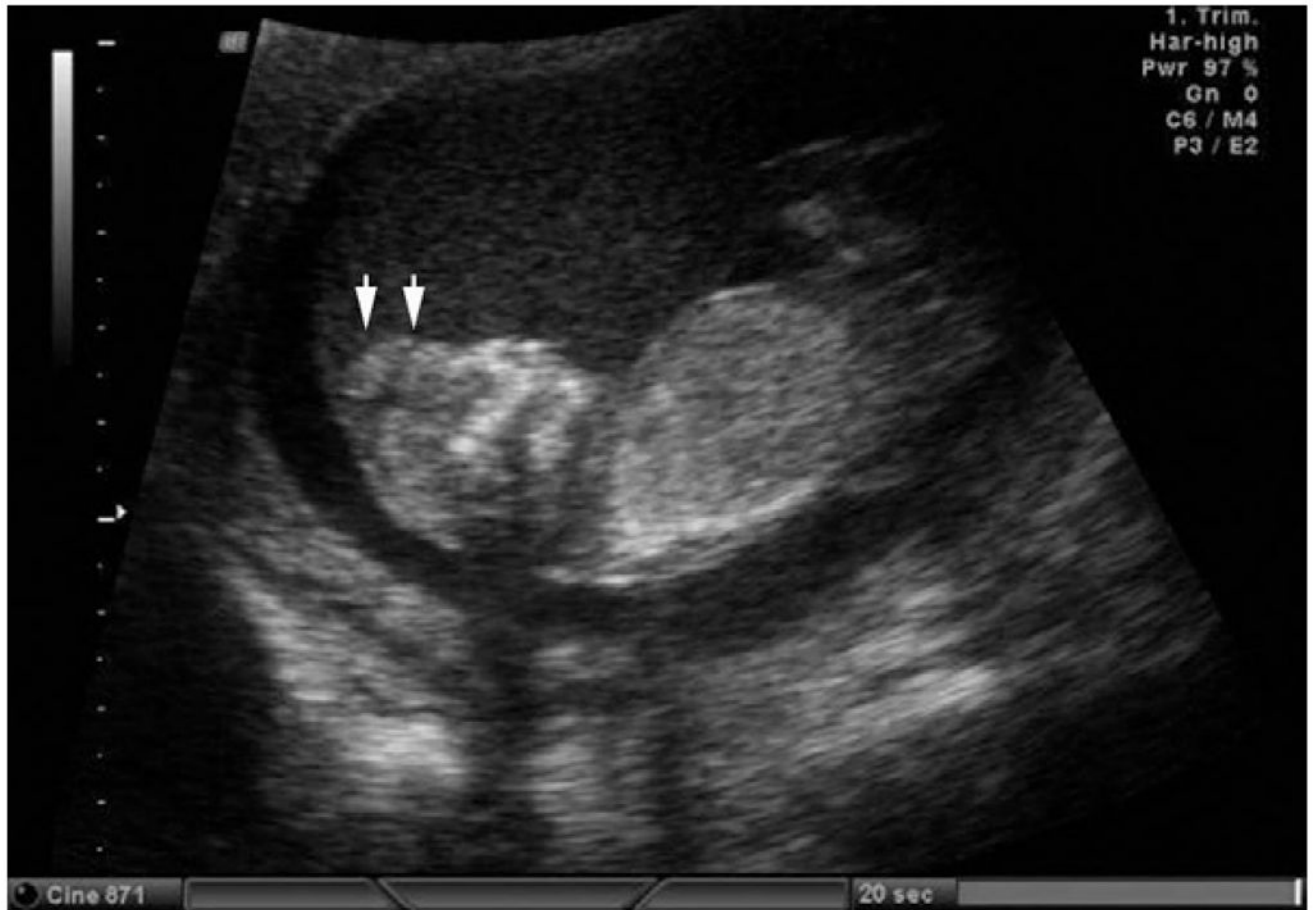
Two-dimensional ultrasonic scanning of anencephaly in the first trimester. Arrows indicate missing forebrain. Modified with permission from; Cameron M, Moran P. Prenatal screening and diagnosis of neural tube defects. *Prenat Diagn* 2009;29:402–11.
